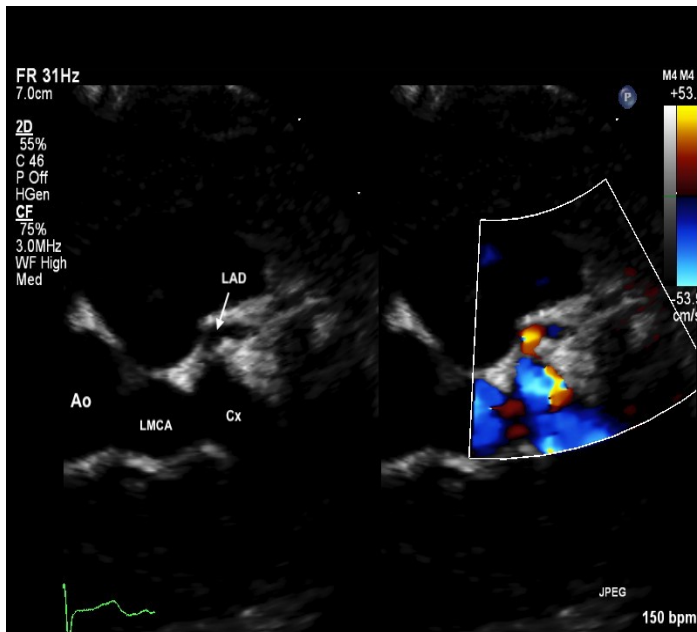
Parasternal short axis view demonstrating the origin of the coronary fistula following along the course of the left circumflex artery territory and the LAD originating from the proximal part of the fistula. (LAD – left anterior descending, Ao – aorta, LMCA – left main coronary artery, Cx – circumflex).
